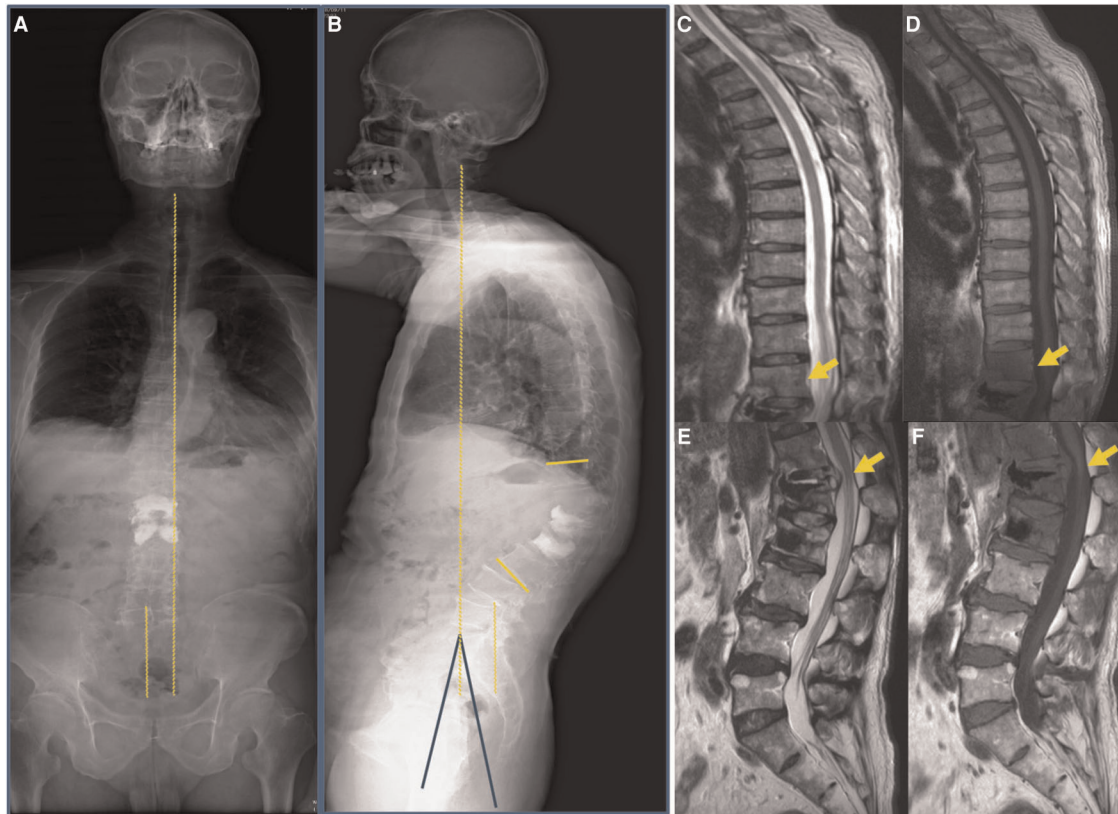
Images were taken at the initial visit to our hospital. (A,B) A full-length radiograph of the patient's spine indicated sagittal imbalance of the spine (Cobb's angle: 45°, PI: 37°, PT: 26°, SS: 11°). (C–F) MRI indicated post-vertebroplasty of L1 and L2 and T12-L2 vertebral body with bone edema (yellow arrow).
